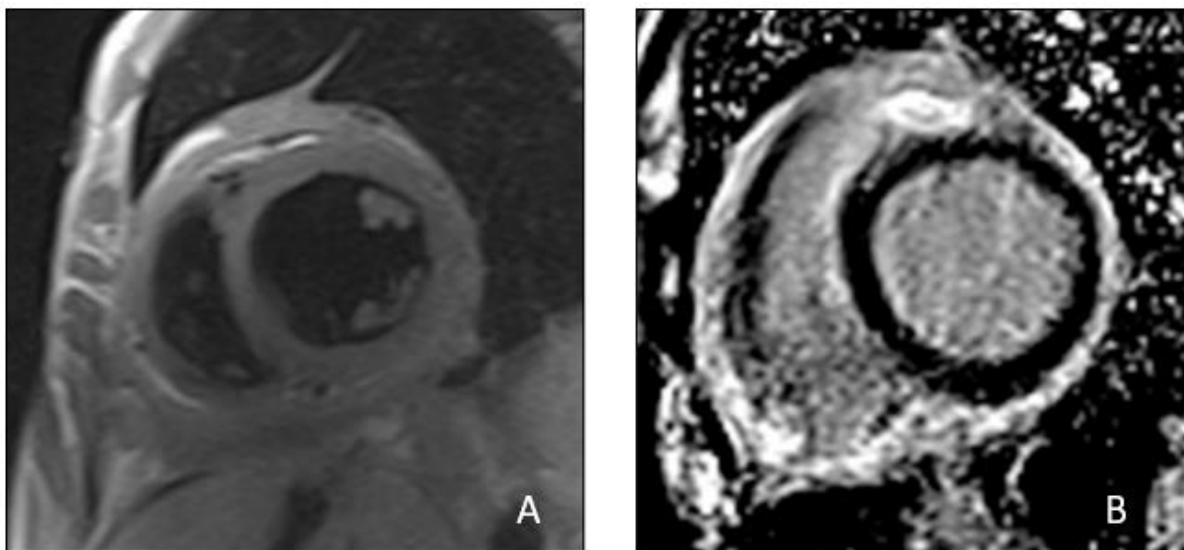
Cardiac magnetic resonance images in TB pericarditis. (A) shows T2 weighted STIR imaging with thickened visceral and parietal pericardium and (B) shows fibrotic pericardial layers after administration of gadolinium (Reproduced with permission of Professor Ntusi NAB, et al. J Cardiovasc Magn Reson 2016;18(Suppl1): Q29.)
